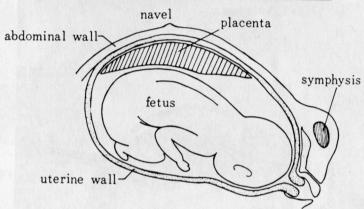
Ultrasonotomogram of the Uterus with 38 Week Pregnancy (Takeuchi)
